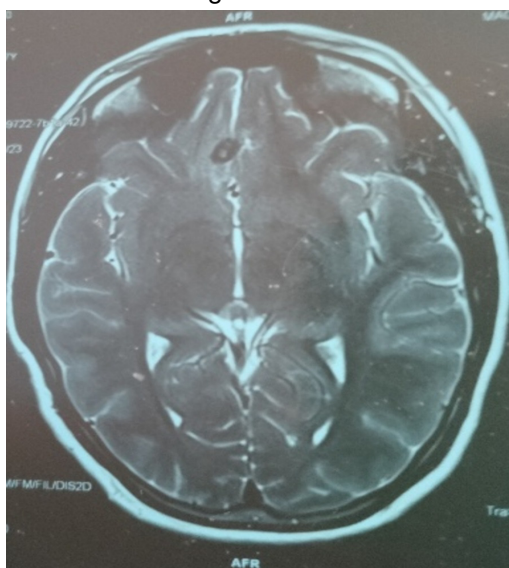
Showing MRI Brain
